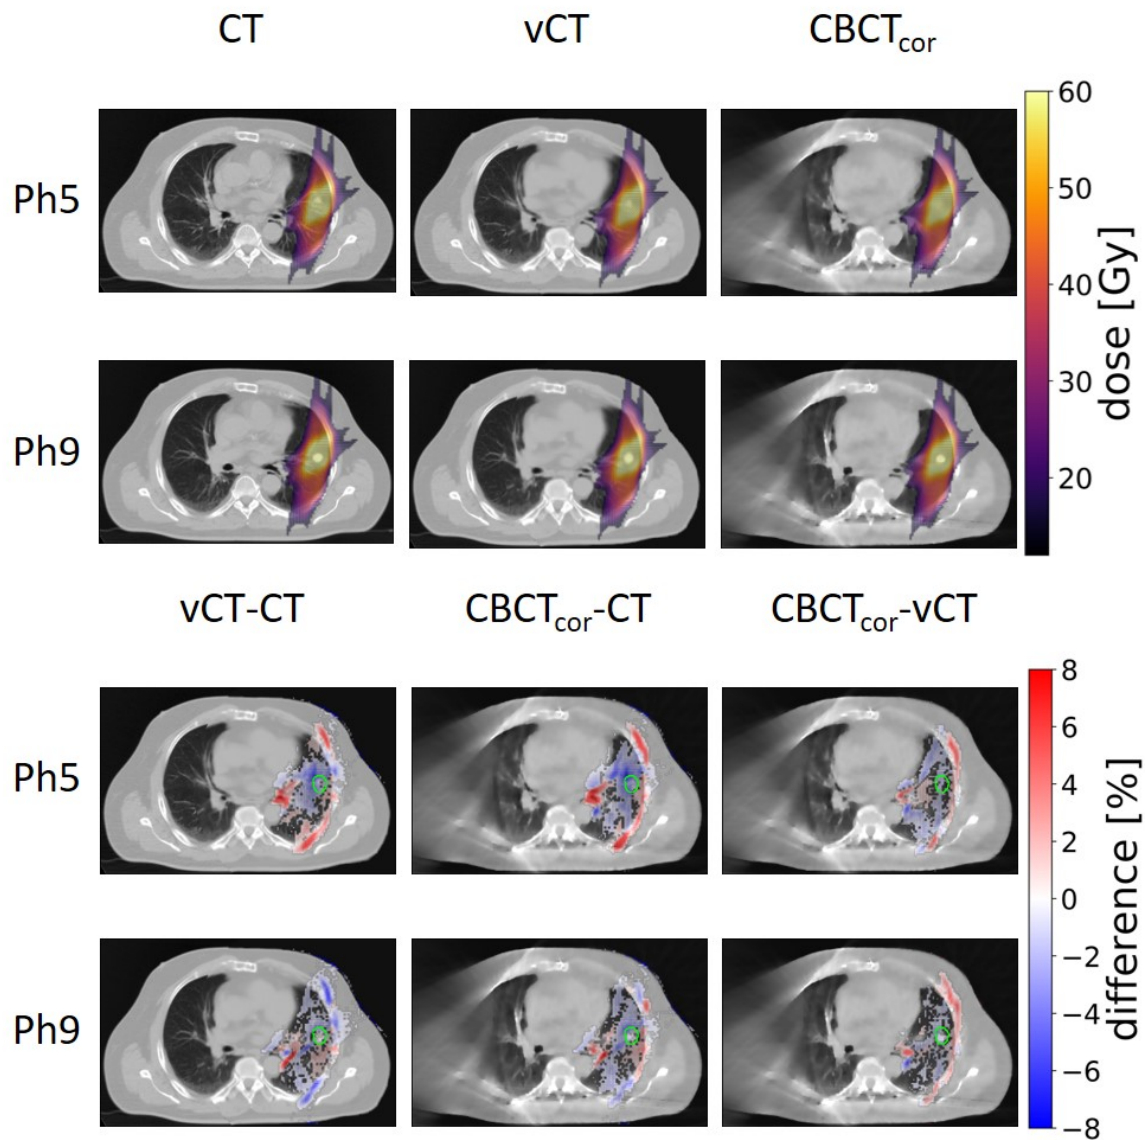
Analogous to figure 7.17 the recalculated proton dose distribution on extremal phases of 4DCT, 4DvCT, and 4DCBCT_{cor} of patient 1 are shown in the top two rows and dose difference plots are shown in the bottom two rows. This patient shows small dose differences.
